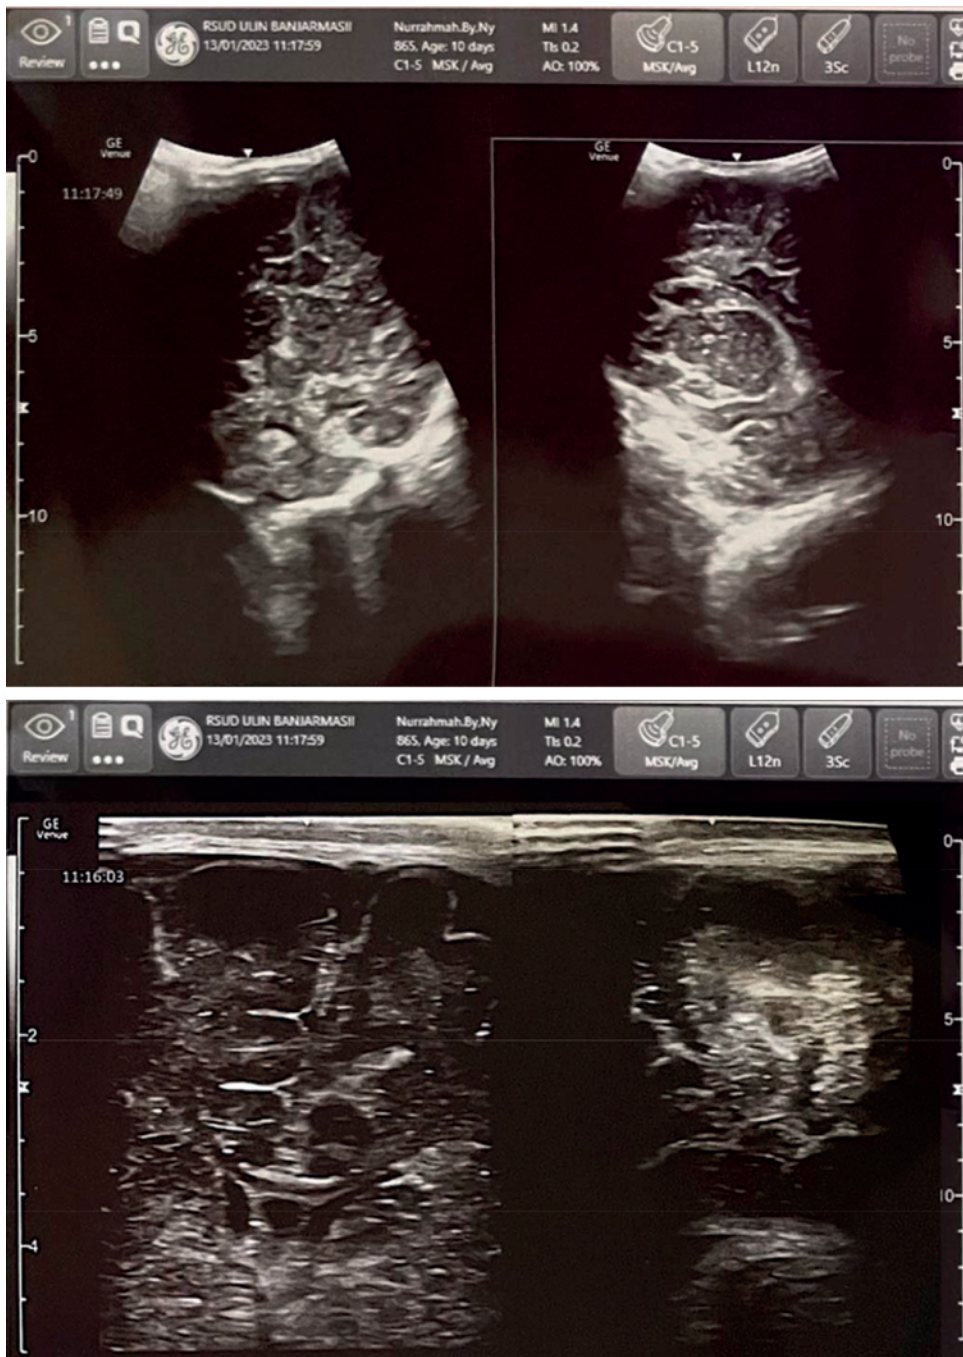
Neonatal cranial ultrasonography result was within normal limits
